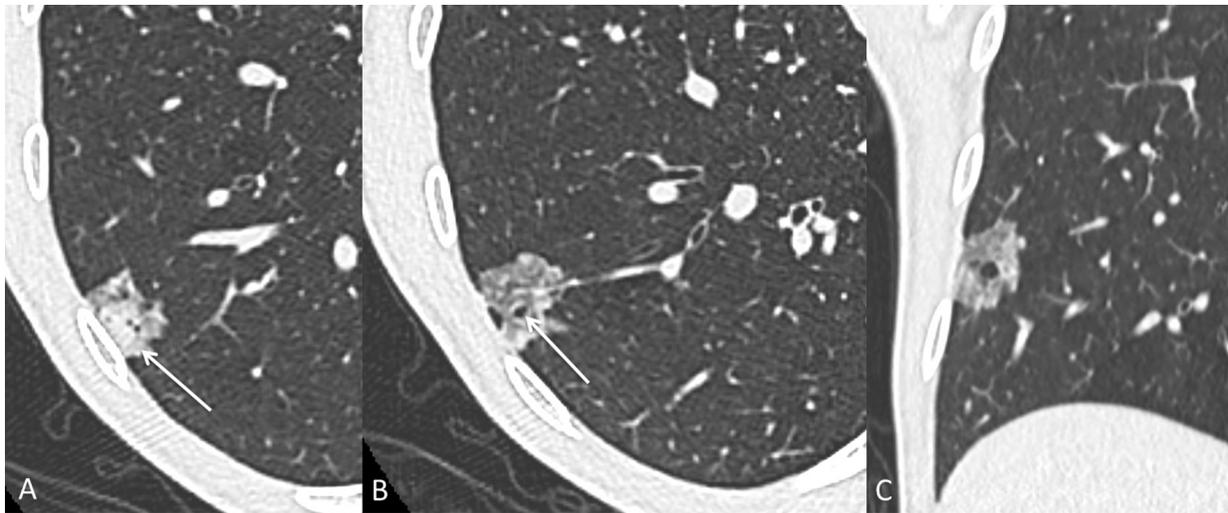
Part-solid nodule within the right lower lobe. (a): transverse high-resolution (0.625-mm section thickness) CT shows a 7-mm solid component (*arrow*) abutting the pleural as well as air bronchogram. (b): transverse high-resolution (0.625-mm section thickness) CT shows pure ground glass component with internal bubble lucencies (*arrow*). (c): Coronal reformation shows internal bubble lucencies.
